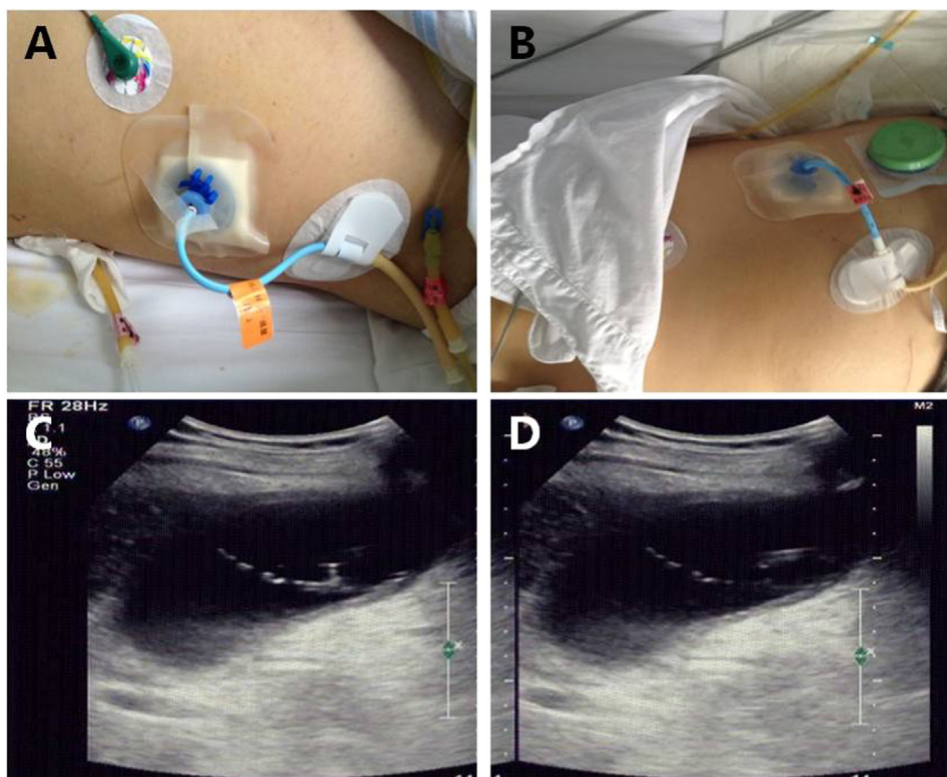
The placement of catheters under APD. (A–B) two catheters respectively in the right paracolic sulci (RPCS) and left paracolic sulci (LPCS); (C–D) in ultrasound images, the catheter in the RPCS.
